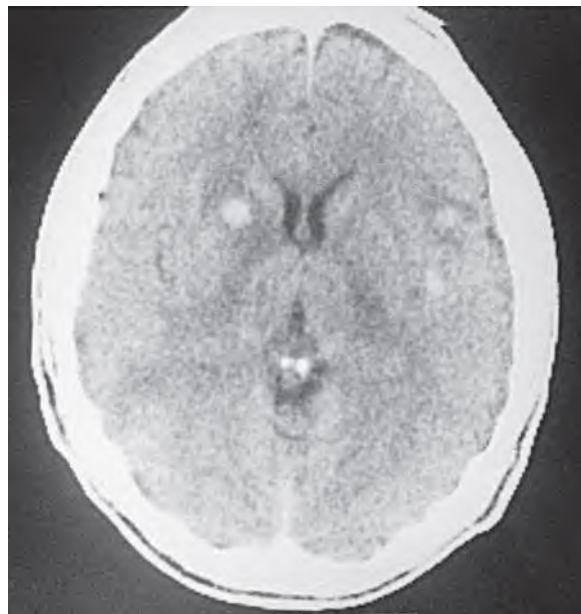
Multiple cerebral cortical densities on computed tomography scan of a patient with tuberculous meningitis.
